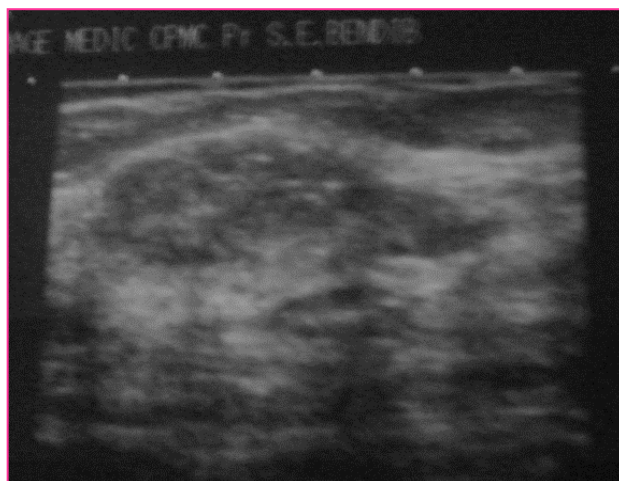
Breast ultrasound: Hypoechoic, heterogeneous, poorly circumscribed mass measuring 38 × 36 mm with posterior attenuation in places.
